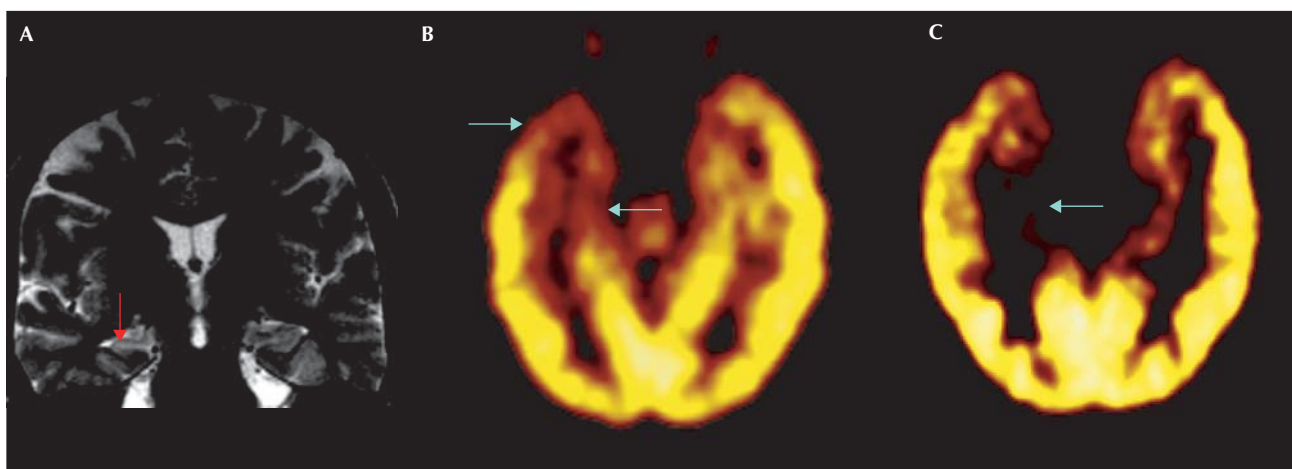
Neuroimaging data in patient 1: A) MRI shows a clear-cut, right hippocampal sclerosis, but no other abnormality; B) FDG-PET demonstrates focal hypometabolism over the right mesial temporal and temporo-polar regions; C) [^{11}C]Flumazenil-PET shows a decreased benzodiazepine receptor density restricted to the right hippocampus.
